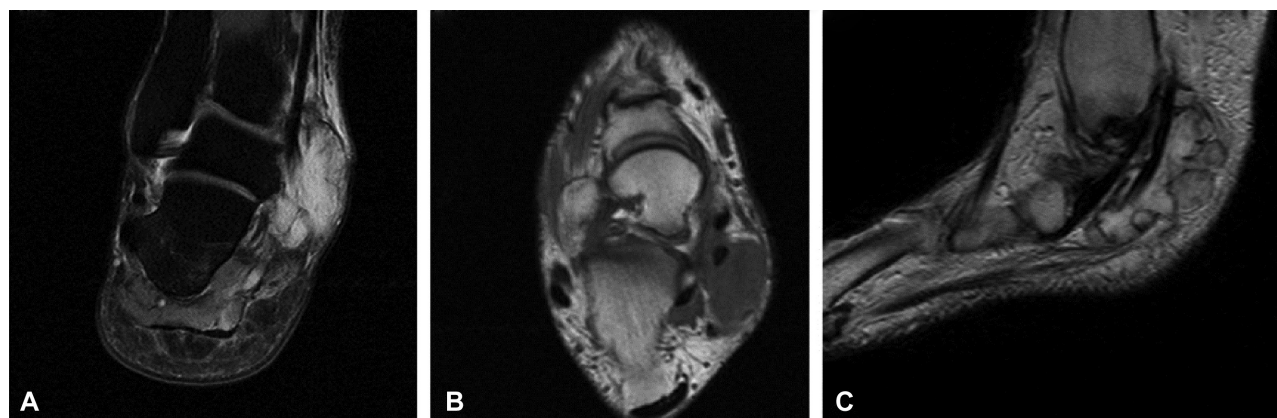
(A) Coronal T2 MRI image of the right ankle showing high intensity signal representing posteromedial mass; (B) axial T1 MRI image of the right ankle showing low intensity signal of mass with involvement of the flexor hallucis longus, flexor digitorum longus, and posterior tibialis tendon; (C) sagittal T1 MRI image of the right ankle showing posteromedial involvement with extension into the plantar tarsal region.
